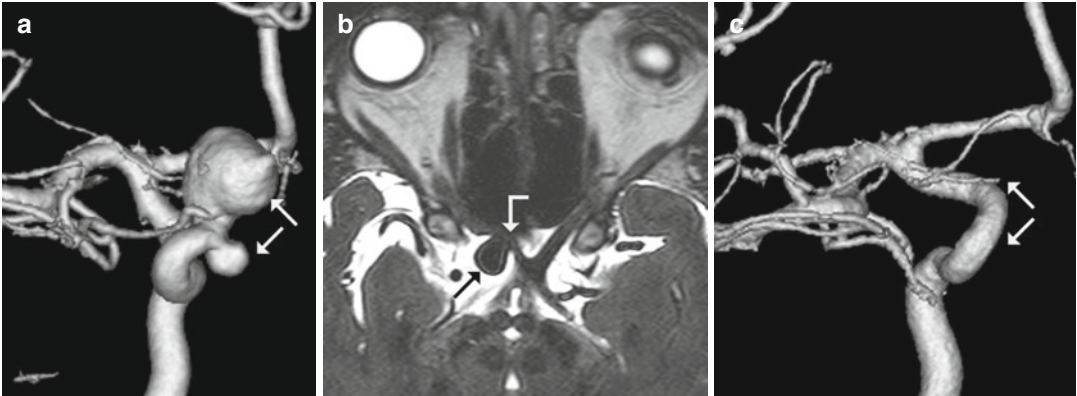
Aneurysm of the Internal Carotid Artery (ICA) – Ophthalmic Artery junction. (a) DSA, right ICA contrast angiography, 3D reconstruction, PA direction. The double aneurysms of the paraophthalmic segment of the ICA are indicated with *arrows*. (b) Heavily T2-weighted (cisternography) spin echo MR image, axial
